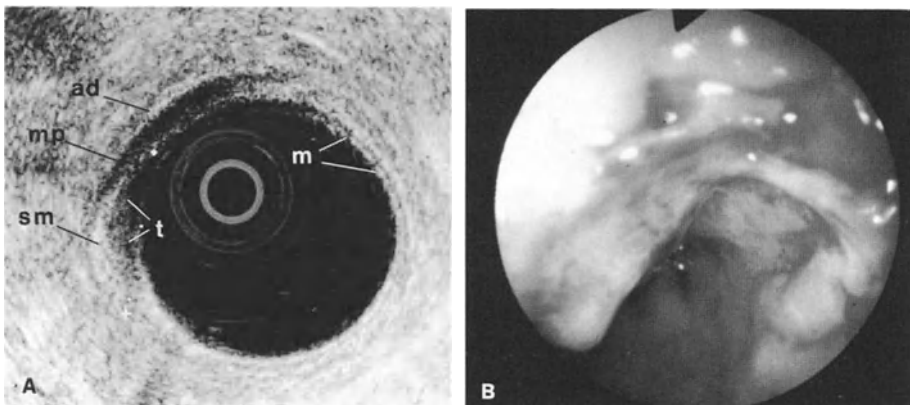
A Endoscopic sonogram showing a sharply demarcated hypoechoic lesion (*t*) in the mucosa (*m*), extending into the submucosa (*sm*) without penetrating into the muscularis propria (*mp*) or adventitia (*ad*). B Corresponding endoscopic image of the ulcerative esophageal carcinoma
